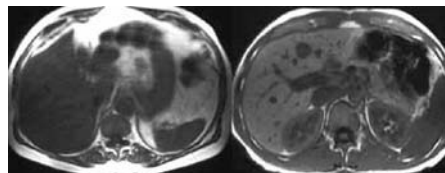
Respiratory and motion artifact degrades the T1-weighted SE (TR 400, TE 11) image on the left. Breath-hold GRE image (FLASH TR 150, TE 4.4, FA 80), right, clearly depicts intrahepatic blood vessels and lesions, and has sharply defined margins.
